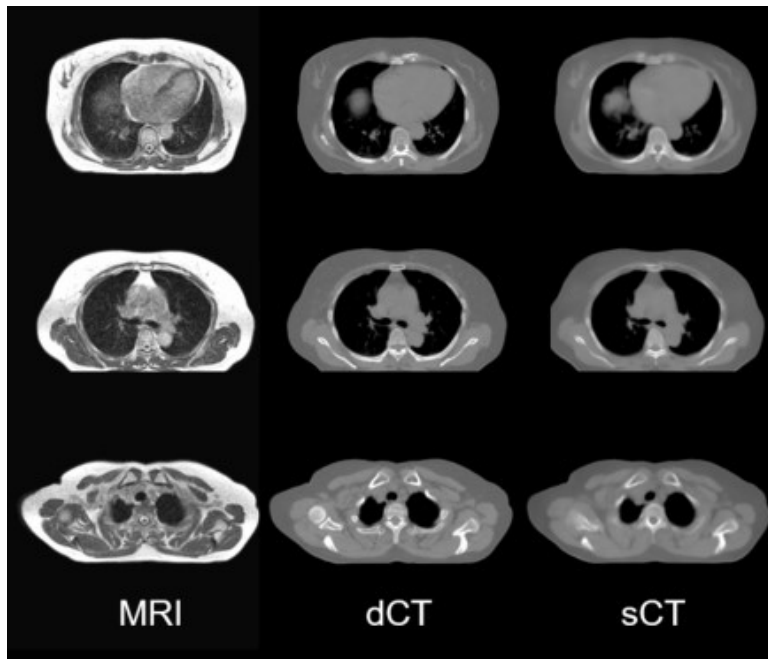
The representative axial slice views of MRI, dCT and sCT for thorax
